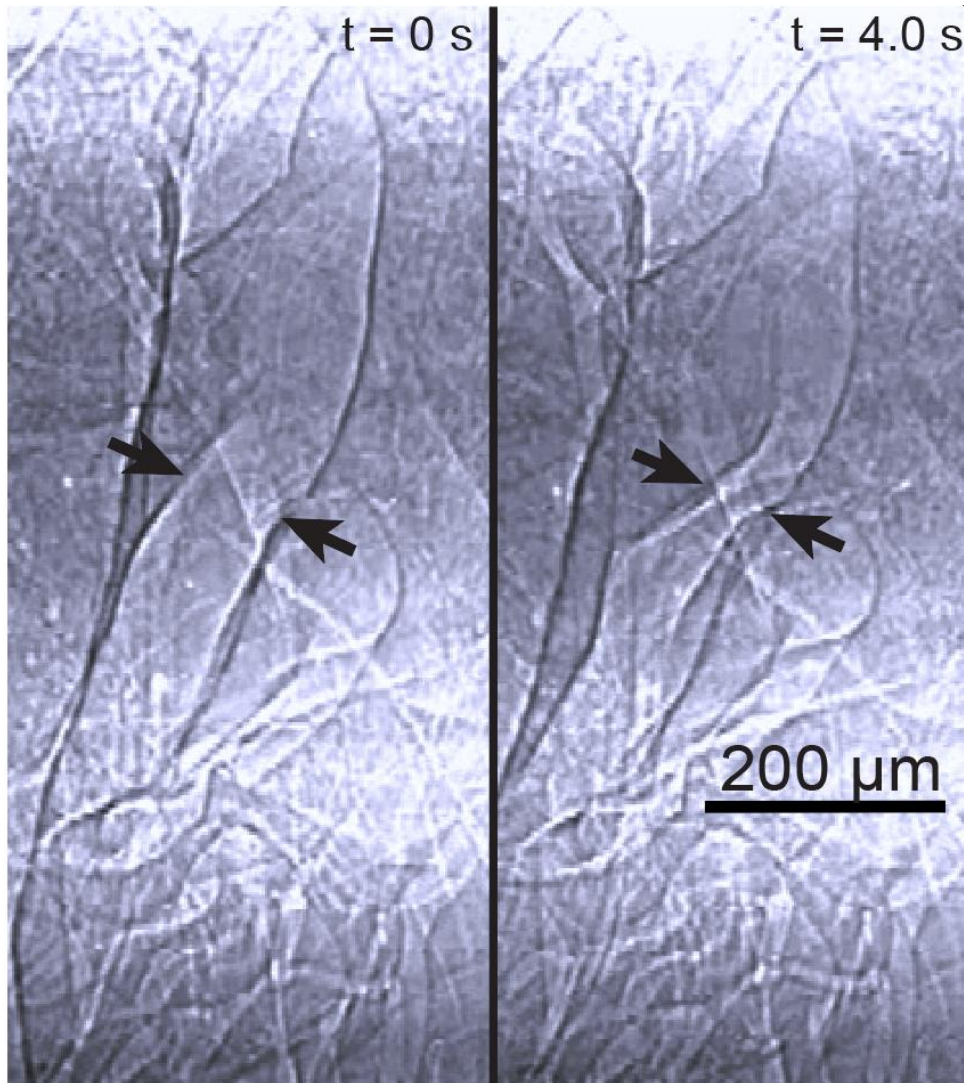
Manual frame-by-frame analysis was used to assess the state of tracheal collapse in phase-contrast x-ray video. Four possible states were scored: Fully expanded (shown on the left), initial collapse, full collapsed (shown on the right), and starting to re-inflate.
